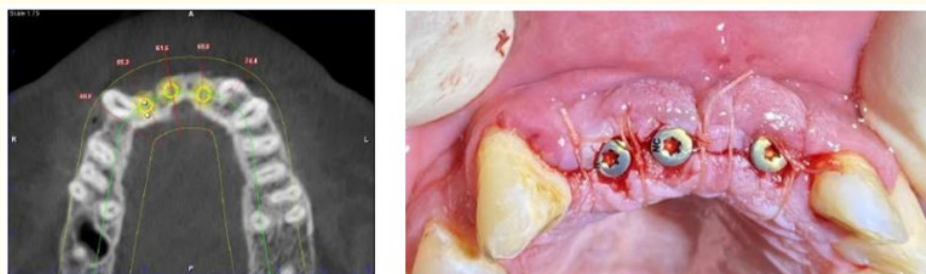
(a) Implants position in the CBCT, (b) Implant position after the surgery.
